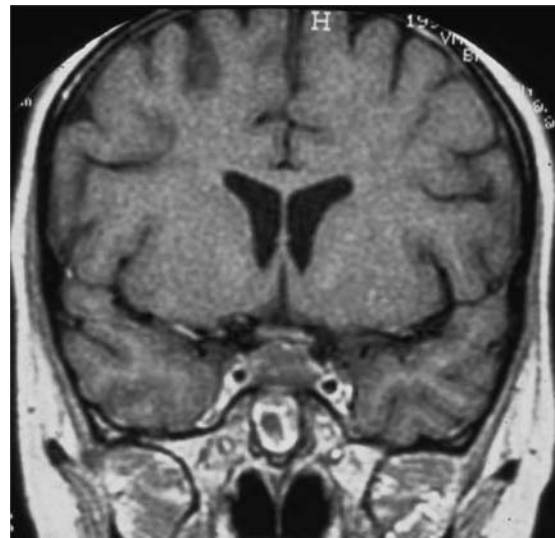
T1 weighted MRI scan coronal section through the pituitary fossa demonstrating a heterogeneous mass in the pituitary fossa with suprasellar extension, but without significant compression of the optic chiasm, visual field assessment was normal. Also seen is thickening of the sphenoid sinus lining
